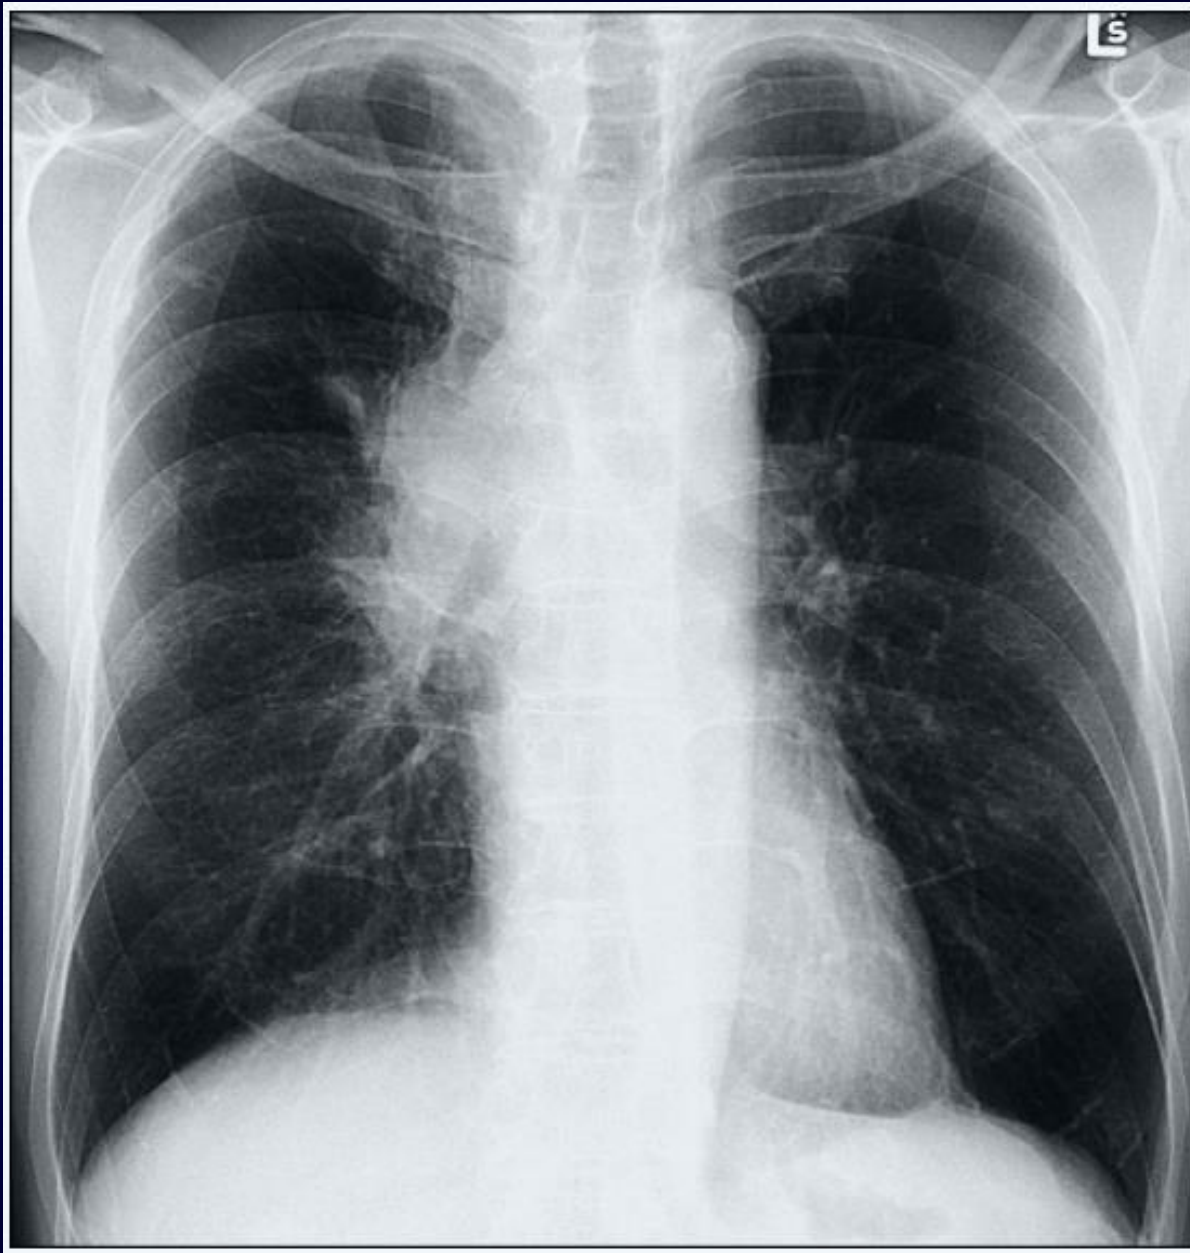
Bronchogenic cyst. Posteroanterior (A) and lateral (B) chest radiographs show a well-circumscribed
